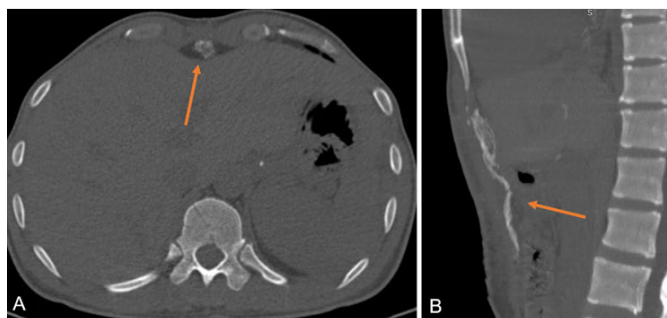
(A) CT scan thoracoabdominal, bone window axial. (B) CT scan thoracoabdominal, bone window sagittal heterotopic ossification at level of laparotomy scar (orange arrow) one month after laparotomy for total gastrectomy after gastric adenocarcinoma.
